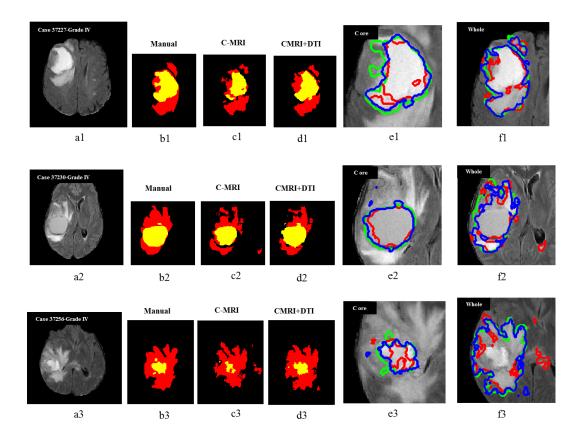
Overall comparison tumour segmentation. A) FLAIR image, B) manual segmentation of the core (yellow region) and oedema (red region) C) segmentation using conventional MRI, D) segmentation using C-MRI+DTI, E) comparison of both methods C-MRI (red), plus DTI (blue) and manual (green) segmentation for core (zoomed in), F) comparison of both methods C-MRI (red), C-MRI+DTI (blue) and manual (green) segmentation for oedema (zoomed in).
